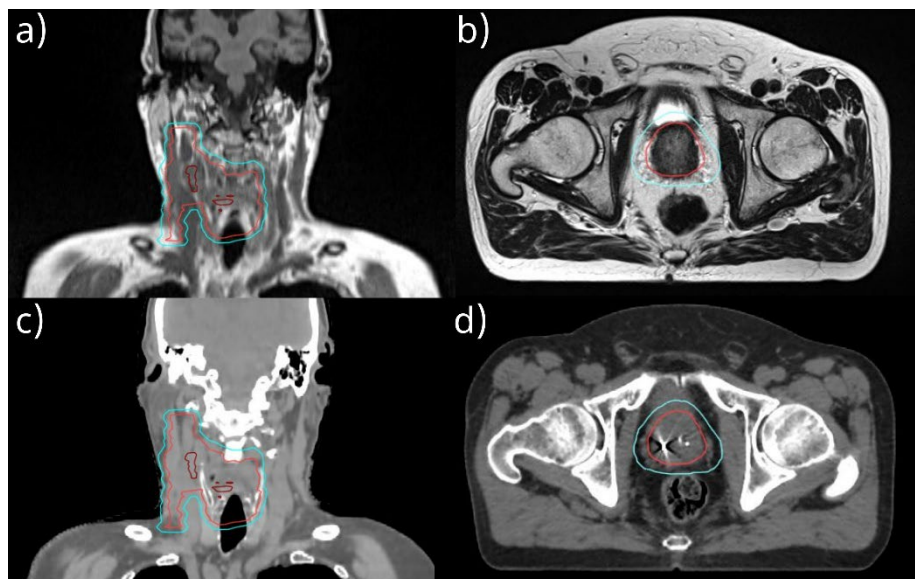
a) T1-weighted head and neck (HN) magnetic resonance image (MRI), b) T2-weighted prostate MRI, and c-d) corresponding computed tomography (CT) images. Delineated are gross target volume in HN (dark red), clinical target volume (light red), and planning target volume (light blue).
